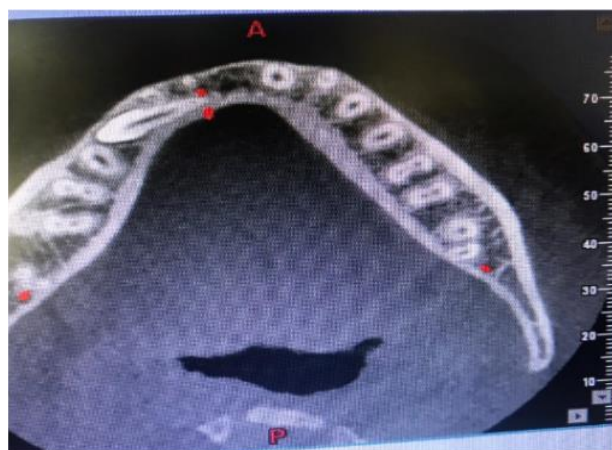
CBCT of the patient showing impacted mandibular first premolar.
